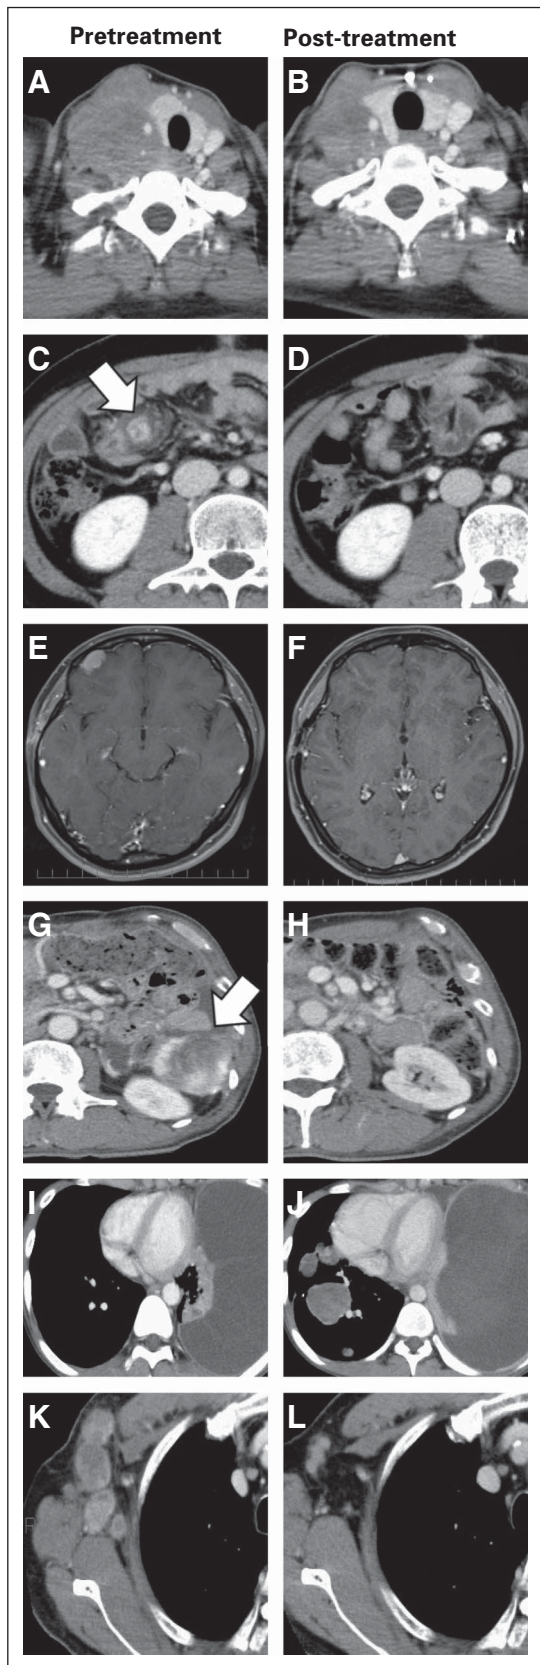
Diagnostic radiographic images of representative cases. (A and B) Patient 1: histiocytic sarcoma showing PR; (C and D) patient 3: IMT (epithelioid) showing CR; (E and F) patient 4: ALK-positive histiocytosis showing CR; (G and H) patient 5: IMT; (I and J) patient 6: osteosarcoma showing PD; and (K and L) patient 7: parotid adenocarcinoma showing PR. ALK, anaplastic lymphoma kinase; CR, complete response; PD, progressive disease; PR, partial response; IMT, inflammatory myofibroblastic tumor.
